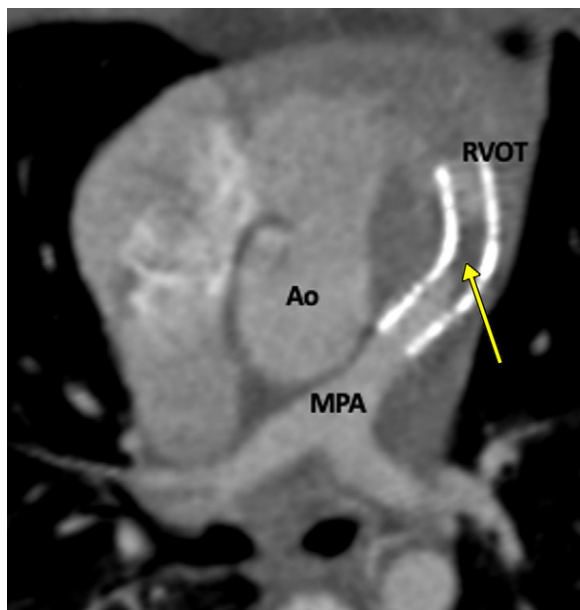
Postprocedural appearance of tetralogy of Fallot after RVOT stent palliation in a 1-year-old boy. Axial oblique contrast-enhanced CT image shows a stent in the RVOT extending into the MPA. A thrombus is observed in the stent (yellow arrow). Ao = aorta, MPA = main pulmonary artery, RVOT = right ventricular outflow tract.
